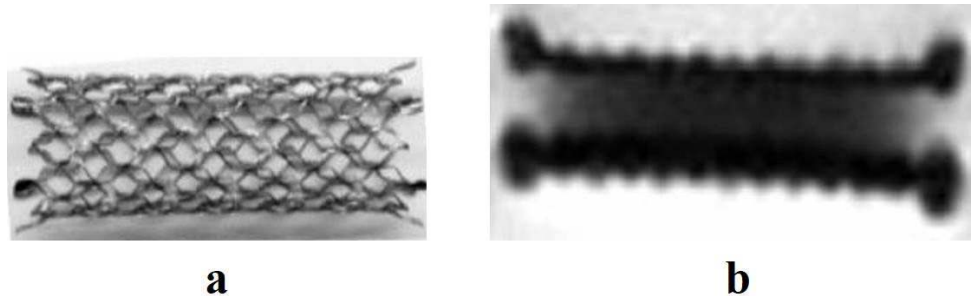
Magnetic resonance Image of stent (a) Stent (b) Laser-cut closed cell (Sinus) (OptiMed, Ettlingen, Germany).
